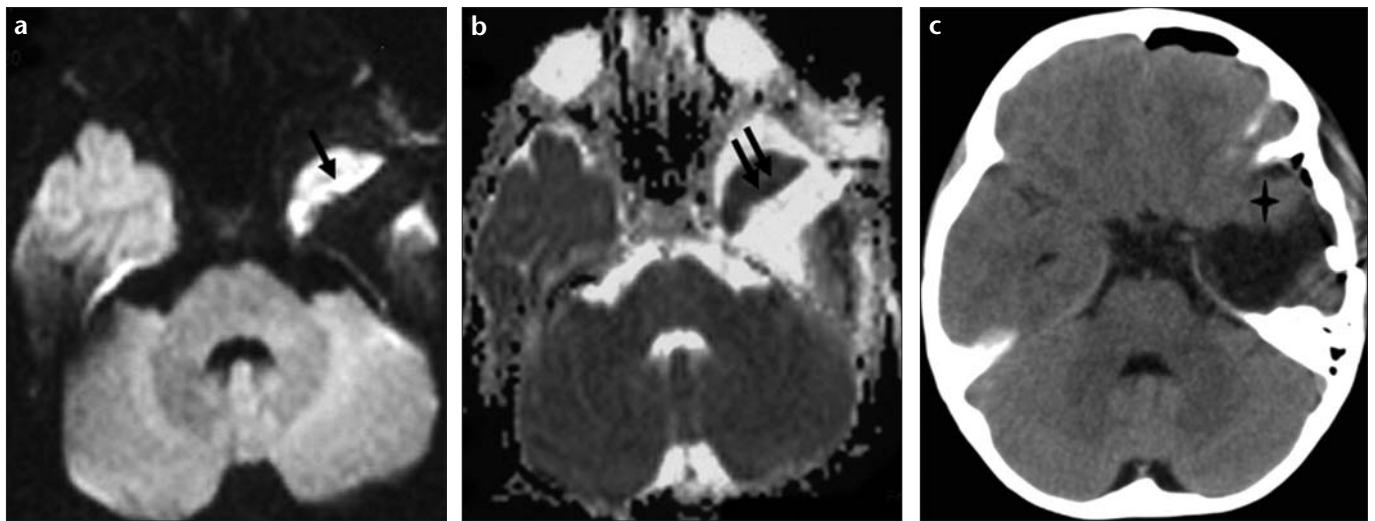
a-c. Case 18. A 9-year-old female. Early postoperative transverse diffusion-weighted (DWI) and computed tomographic (CT) images of a primitive neuroectodermal tumor (PNET). Transverse DWI (a) with corresponding ADC (apparent diffusion coefficient) map (b), which indicates restricted diffusion (single arrow in a and double arrows in b) around the resection cavity. There was no blood around the cavity (asterisk) as shown on transverse CT scan (c).
